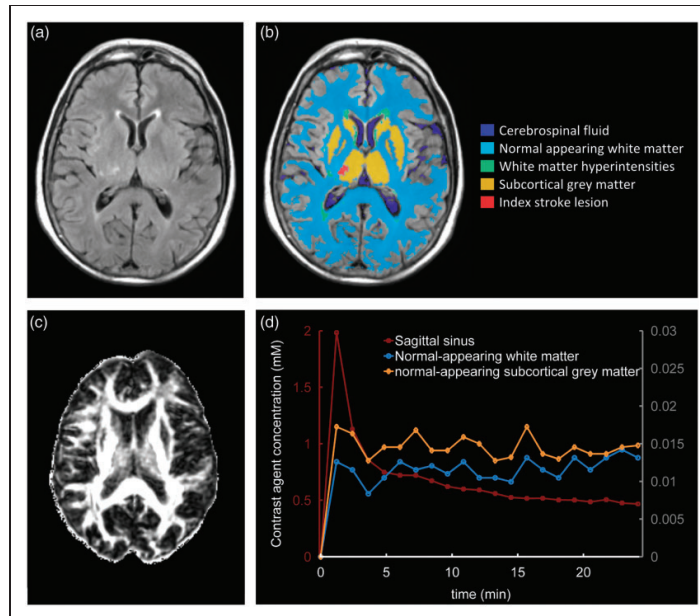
Representative magnetic resonance imaging (MRI) data and tissue segmentation. (A) Fluid-attenuated inversion recovery (FLAIR) image, (B) tissue masks superimposed on FLAIR image, (C) fractional anisotropy map, (D) contrast agent concentration curves obtained from dynamic contrast-enhanced MRI (DCE-MRI); y-axes scales for the sagittal sinus plasma concentration and normal-appearing tissue concentration curves are shown on the left and the right, respectively.
